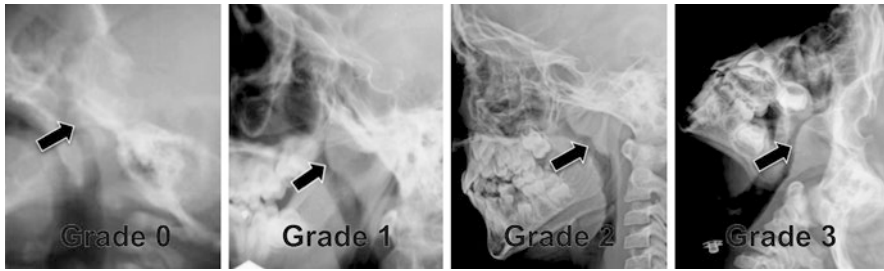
X-ray nasopharynx showing 0–3 grades of adenoidal hypertrophy causing airway obstruction
